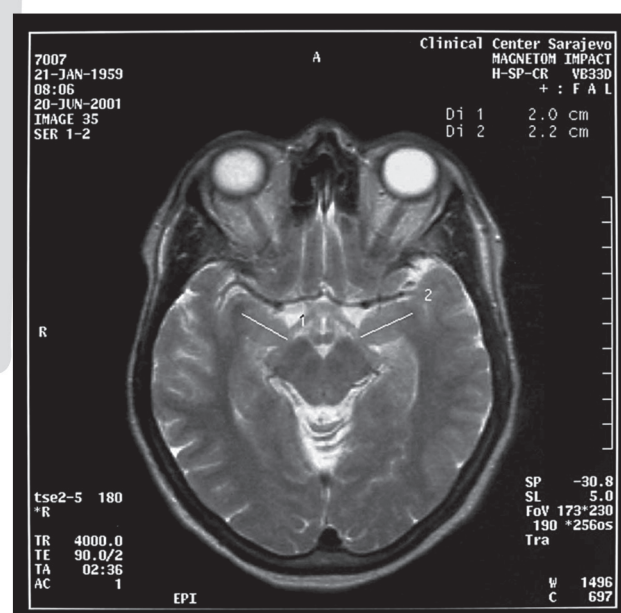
Axial MRI scan lateromedial diameter of amygdale complex
